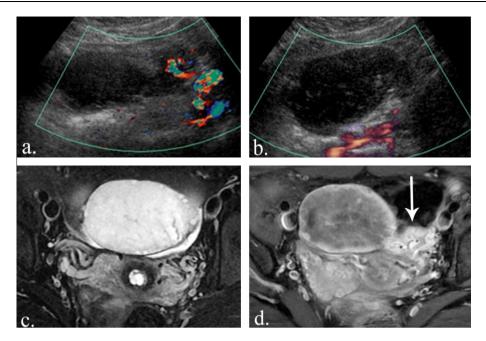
Ovarian torsion: a 24 year old female patient presented with left iliac fossa pain. (a & b) Pelvic ultrasound revealed a left adnexal mass that was thought to be adjacent to the left ovary that showed internal vascularity by color Doppler and further MRI was recommended for adnexal mass characterization. (c) Axial T2 weighted fat sat images revealed an enlarged left ovary with peripherally situated subcentemetric follicles and minimal surrounding free fluid. (d) Axial post contrast T1 weighted image with fat saturation revealed enlarged left ovary with poor central enhancement and engorgement of its vascular pedicle seen (arrow in d) and this was misinterpreted in ultrasound as the normal ovary yet retrograde, it was known to be the whirlpool sign of the twisted vascular pedicle in ovarian torsion.
